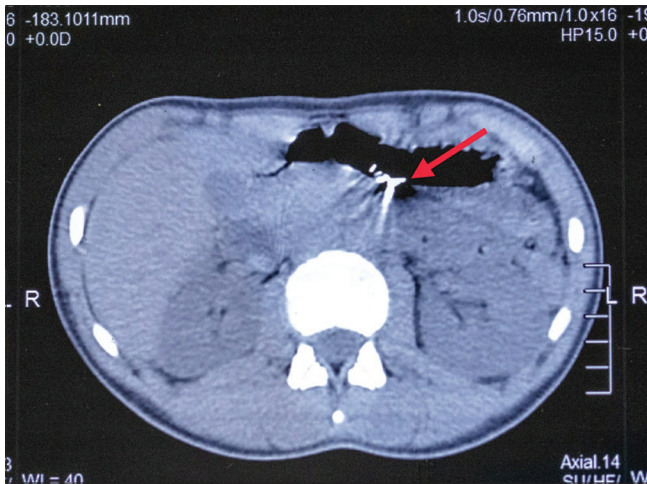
CT image showing band as a hyper dense field (red arrow).
